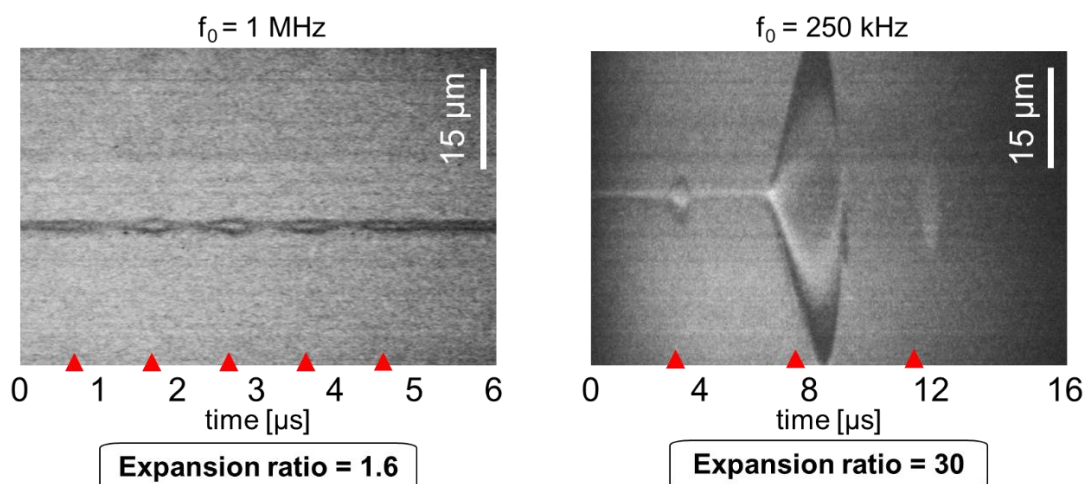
Effect of low frequency ultrasound on microbubbles oscillations. Ultra high-speed camera streak images of oscillating MBs with a resting radius of $1.5 \mu\text{m}$ for a peak negative pressure of 400 kPa at a center frequency of 1 MHz and 250 kHz [57].
